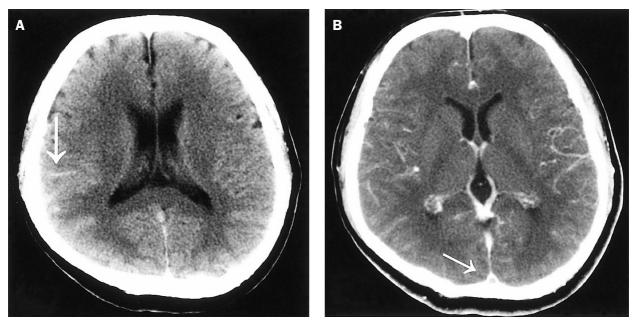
(A) Non-contrast brain computed tomography (CT) showed acute subarachnoid hemorrhage over the right parietal sulci (arrow). (B) Brain CT with contrast revealed an empty delta sign in the superior sagittal sinus thrombus (arrow). Axial contrast-enhanced CT demonstrated a filling defect in the center of the superior sagittal sinus as it approached the confluence of the sinuses.
